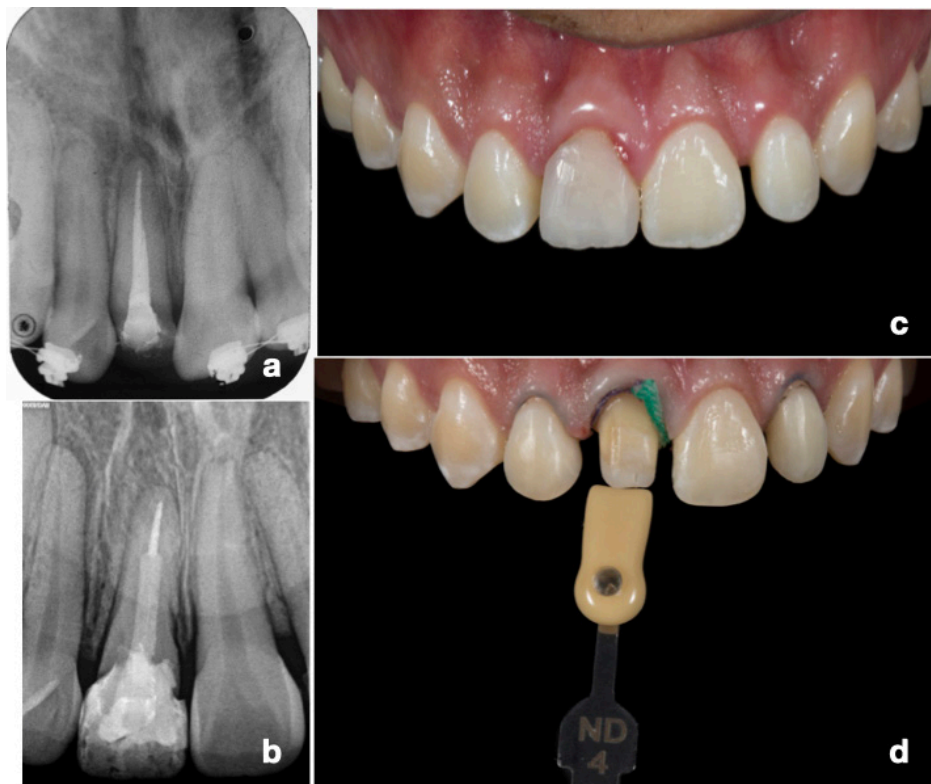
Treatment progress. A. Final radiograph of root canal treatment. B. Radiograph of the reconstruction with temporal stratification. C. Healing of the surgical procedure. D. Colour taking of the nuclei.
